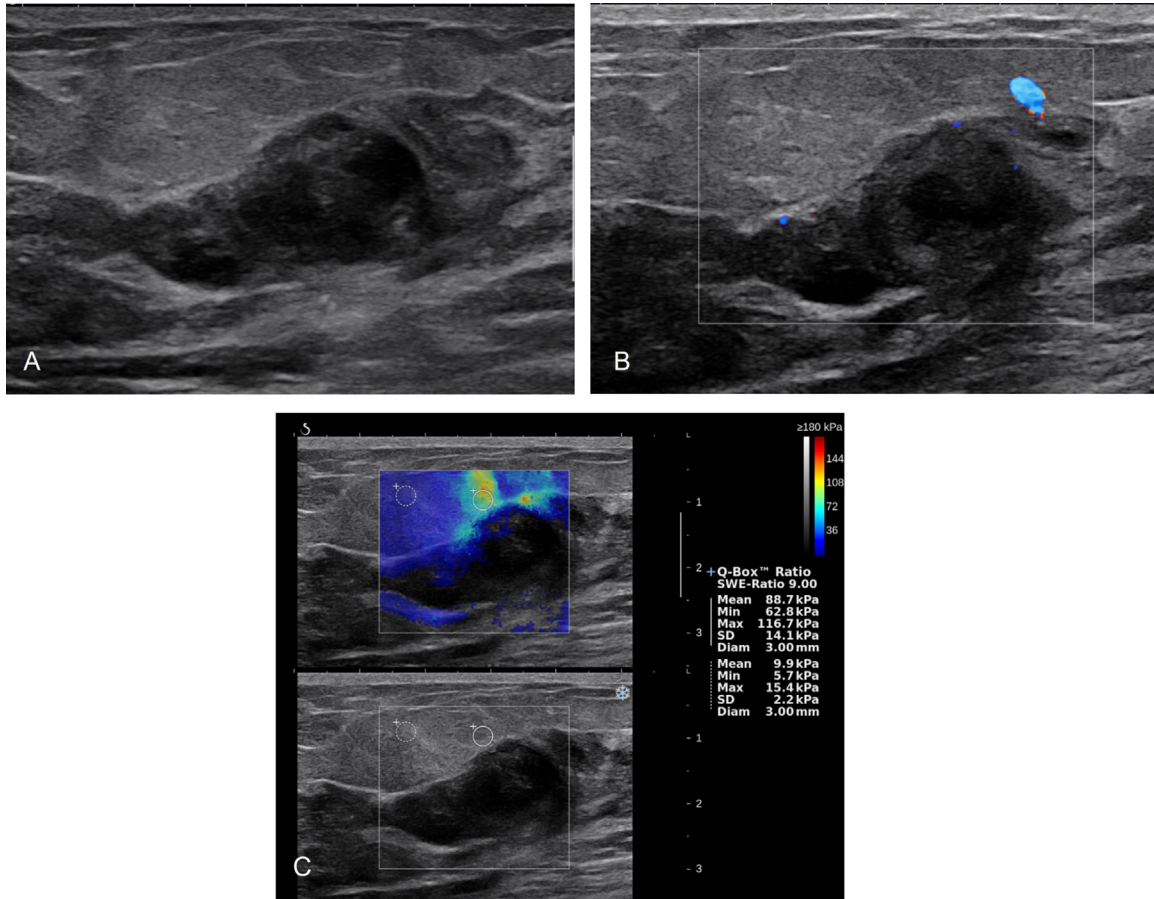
US of a 67-year-old woman with breast lymphoma. (A) Conventional US shows an irregular hypoechoic mass with circumscribed and partially indistinct margins in upper outer area of right breast. (B) Color Doppler imaging shows vessels in the peripheral portion of the mass. (C) SWE image shows E_{\max} of 116.7 kPa, E_{mean} of 88.7 kPa, and mean elasticity ratio of 9.0.
